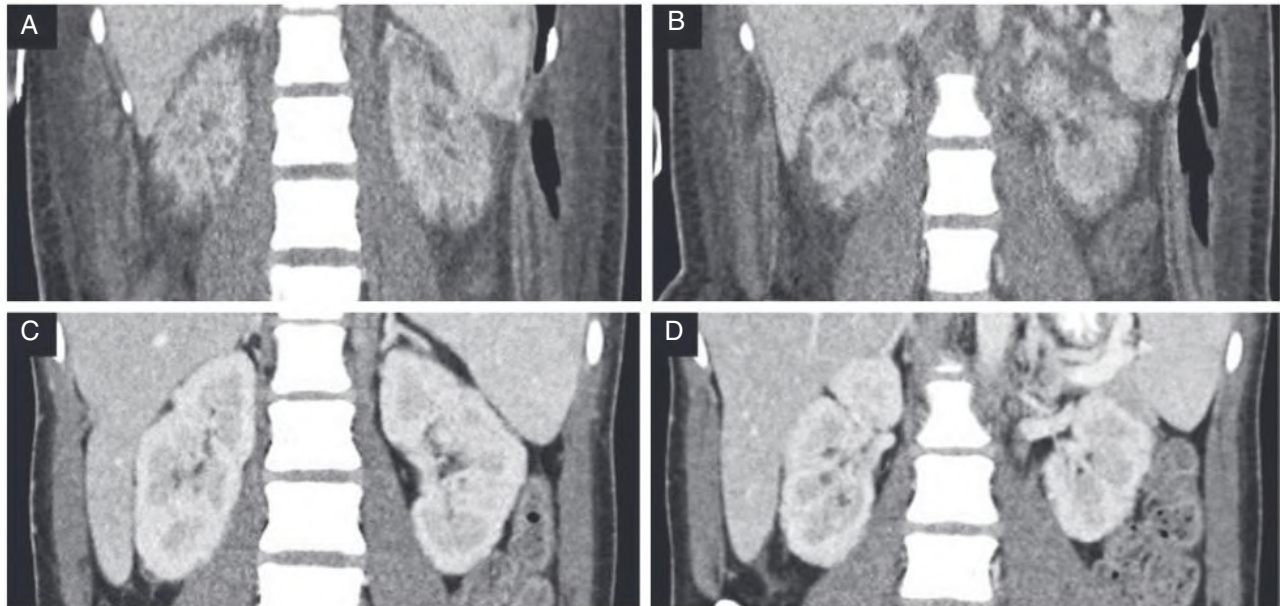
Imaging Showing Bilateral Acute Cortical Necrosis of the Kidneys. (A–B) Contrast-enhanced computed tomography (CT) scanning coronal images disclose remarkable distortion of the anatomic appearance of both kidneys, including irregular margins, presence of hypodensity of the renal cortices and patchy medullary enhancement. (C–D) After 60 days, repeat CT scanning (coronal view) shows complete resolution of previously observed kidney abnormalities. (From Luo X, Cielo AG, and Velez JCO. Abnormal imaging findings of the kidneys in a patient with shock. *Kidney360*. 2020;1[12]:1462–1463.)
